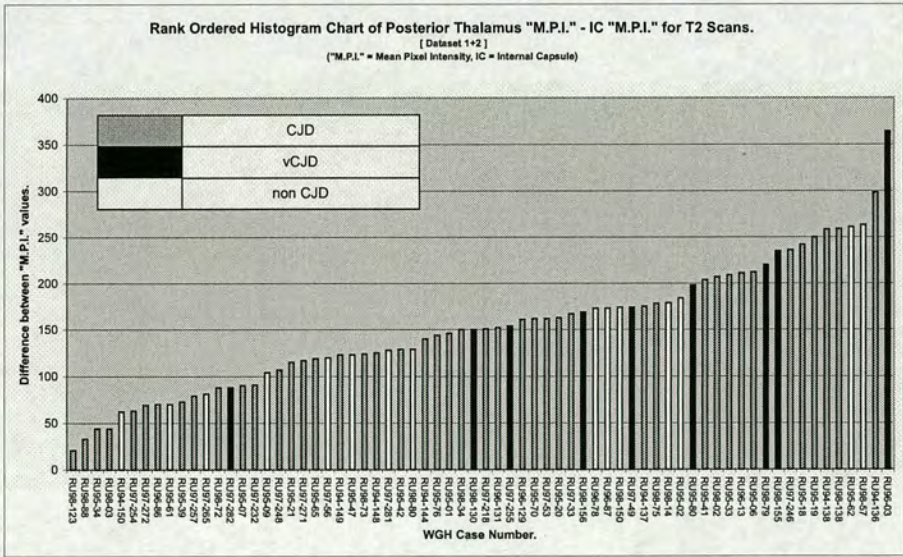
Posterior Thalamus Tests: Rank ordered histogram of the difference between the Posterior Thalamus region "M.P.I." and the Internal Capsule "M.P.I." values for the T2 weighted MRI scan-data from datasets 1 & 2 combined.
